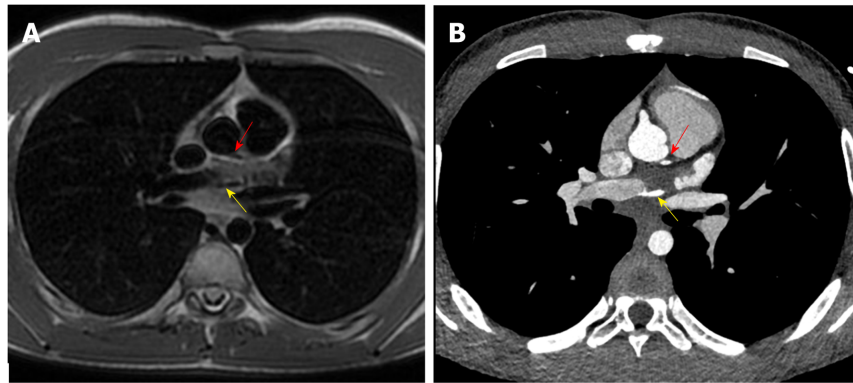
Origin of left circumflex artery and small diagonal branch. A: Origin of left circumflex artery from right pulmonary artery (yellow arrow) and origin of a small diagonal branch from the left coronary sinus for the left ventricle (red arrow) evaluated with 1.5 T cardiac magnetic resonance; B: Origin of left circumflex artery from right pulmonary artery (yellow arrow) and origin of a small diagonal branch from the left coronary sinus for the left ventricle (red arrow) evaluated with third generation dual source cardiac computed tomography.
